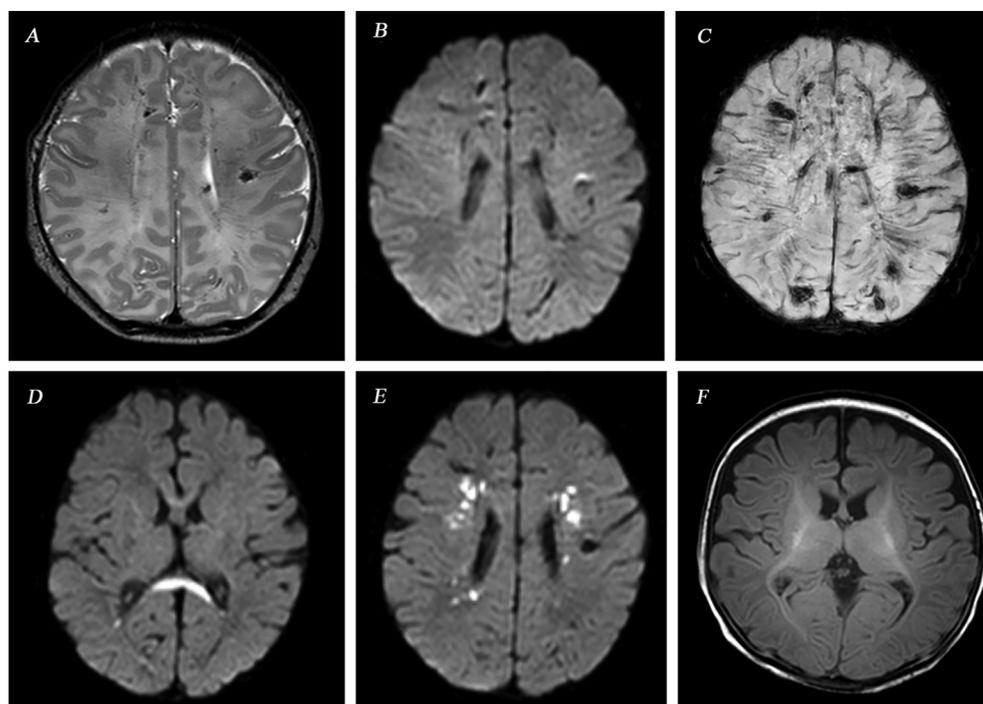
Radiological evolution of PWMLs over 3 months in a term infant with sinovenous thrombosis. MRI, axial plane, performed on day 3 (a–c), day 8 (d,e) and at three months (f). On day 3, low signal intensity lesions are seen on T2 (a), no clear increased signal intensity lesions are seen on the DWI (b) but many low signal intensity lesions are seen on SWI (c) suggestive of haemorrhagic PWMLs. By day 8, d) the DWI showed restricted diffusion in the corpus callosum (d) together with e) predominantly ischaemic lesions in a different distribution (e). The follow-up MRI at 3 months of age, f) showed evidence of white matter loss. BSID-III at 24 months was normal (cognitive and motor score both 115).
